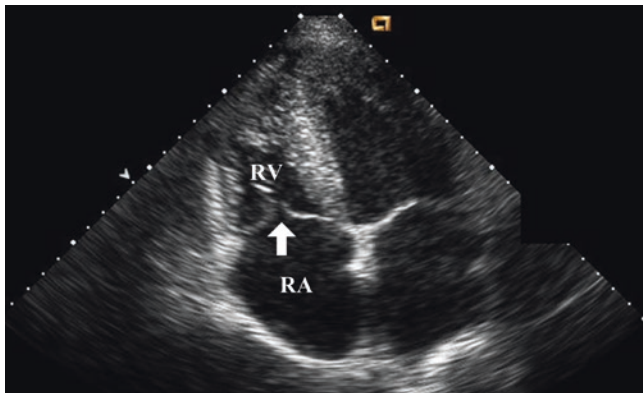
Structural assessment of the tricuspid valve using point-of-care ultrasound. Tricuspid valve assessment can be accomplished in different views including parasternal, apical and subcostal views. The apical four-chamber view is commonly used for point-of-care ultrasound. Tricuspid regurgitation is a relatively common finding. Most commonly, moderate-to-severe tricuspid regurgitation is secondary to right ventricular dilation. In this example, the right ventricle (RV) and right atrium (RA) are enlarged. A coaptation gap can be seen between the tricuspid valve leaflets in systole due to tricuspid annular dilation. See also Video 20.8
